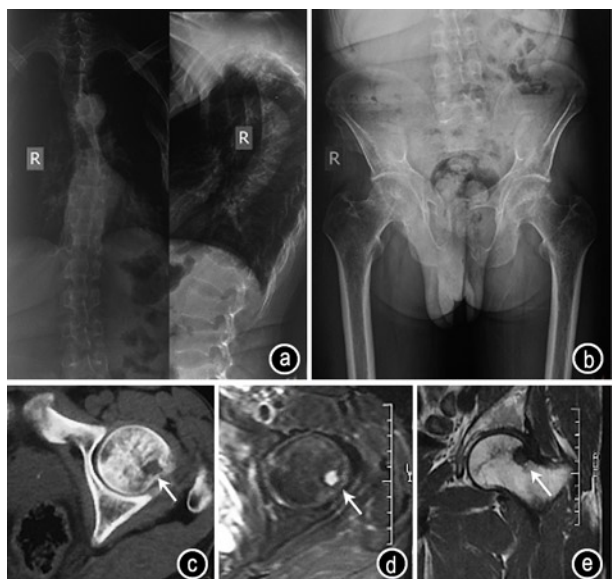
(a and b) X-ray of Case 2 showing severe osteoporosis and spinal deformity; (c–e) Further CT/MRI revealed a suspicious lesion in the left collum femoris; the low-density tumor was circular, about 0.8 cm in diameter, and was not visible by PET/CT
